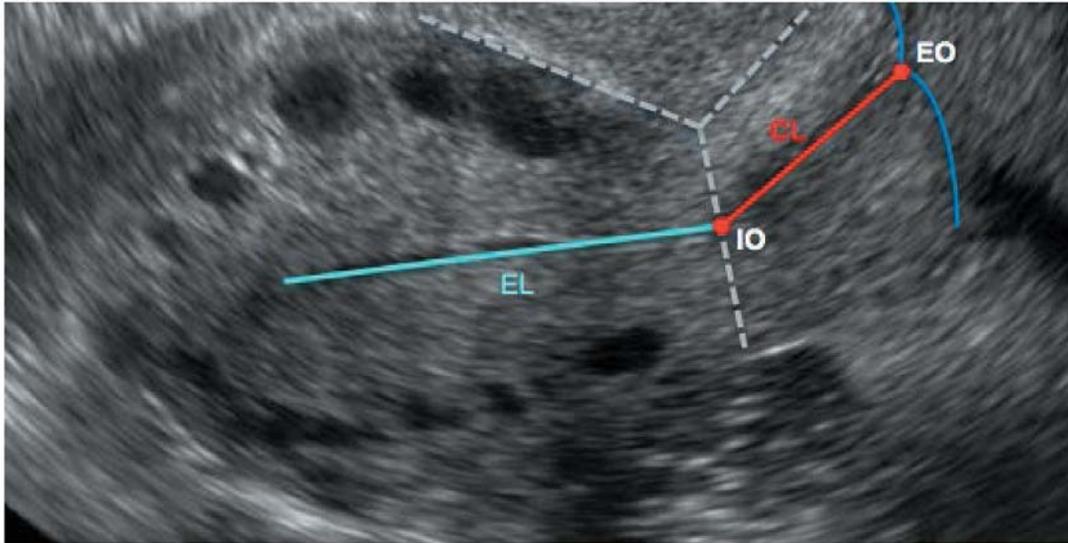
Ultrasound measurement of cervical length. CL=Cervical length, EL=endometrial line, IO=internal os, EO=external os.
